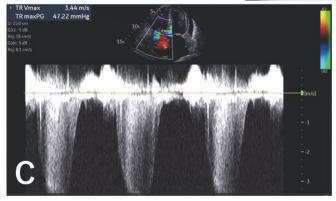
Radiologic images and echocardiography.
